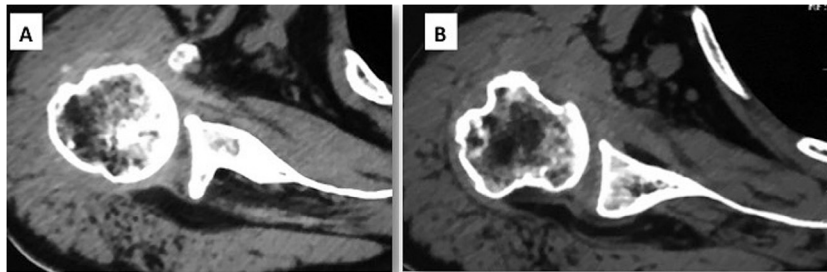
Typical computed tomography scan of an isolated loss of active external rotation (ILER) patient. (A) Fatty infiltration stage 4 of the infraspinatus muscle, whereas the subscapularis is intact. (B) Complete atrophy of the teres minor.
